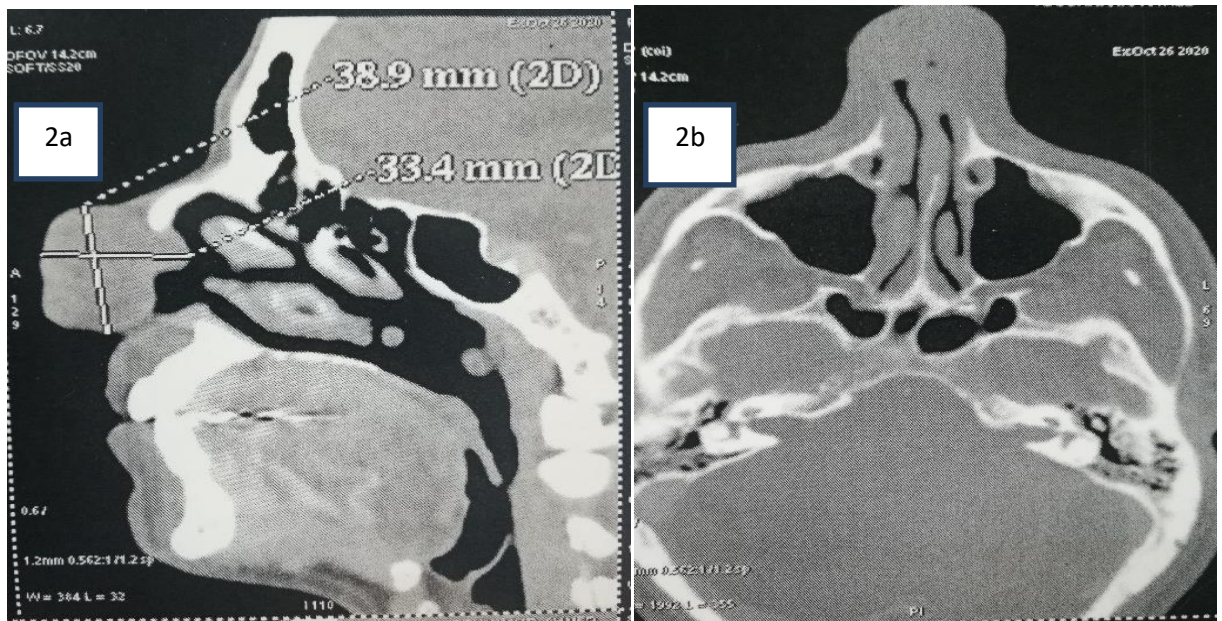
Facial CT scan showing a mass of the nasal pyramid measuring 38.9mm*33.4mm, partially filling the whole left nasal cavity.
